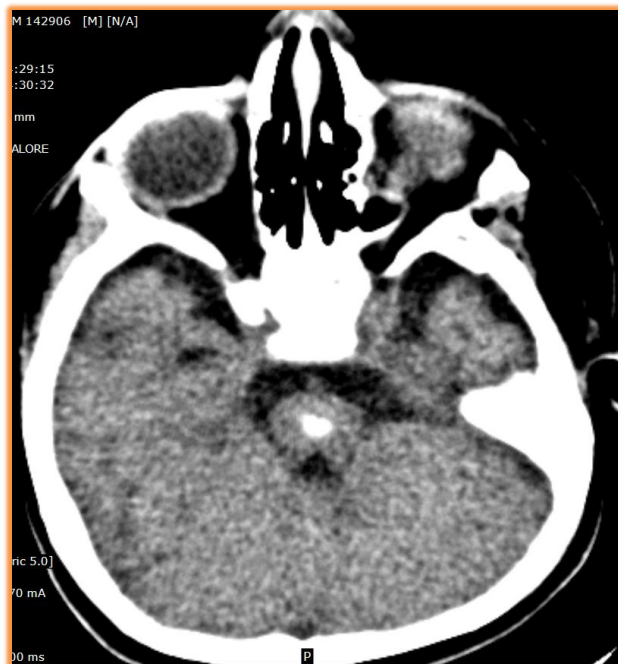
Nonenhanced CT scan in a 4-year old known case of hypothyroidism, shows calcification in pons region.
